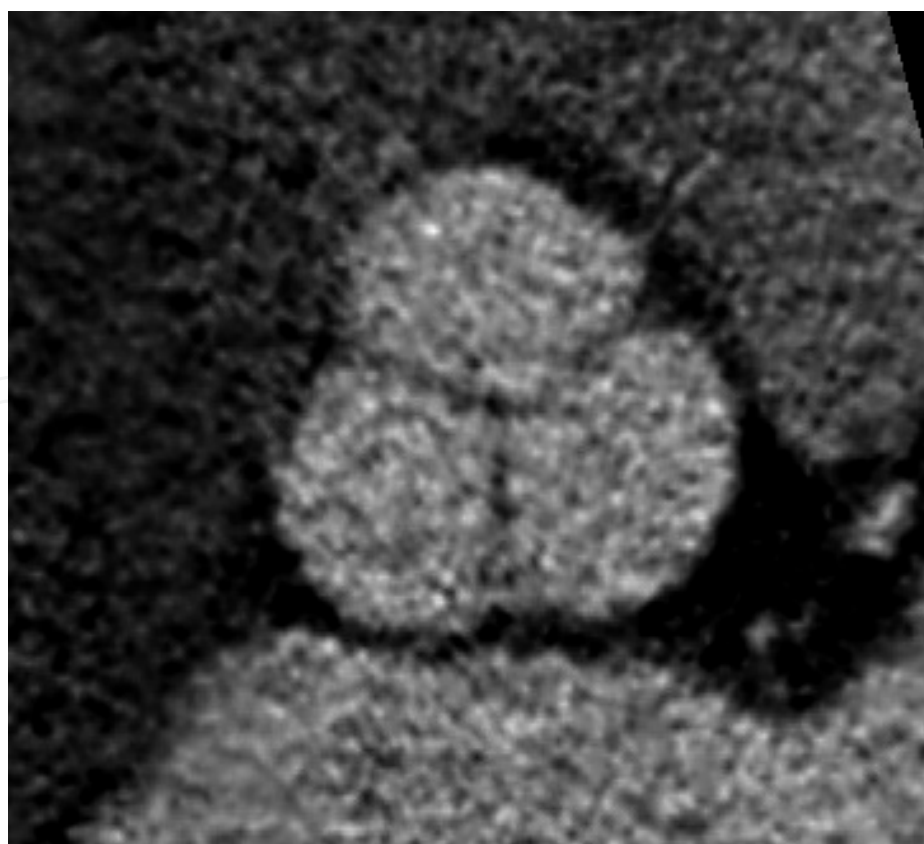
Two-dimensional computed tomographic view of three sinuses of Valsalva like a three-leaflet clover.
